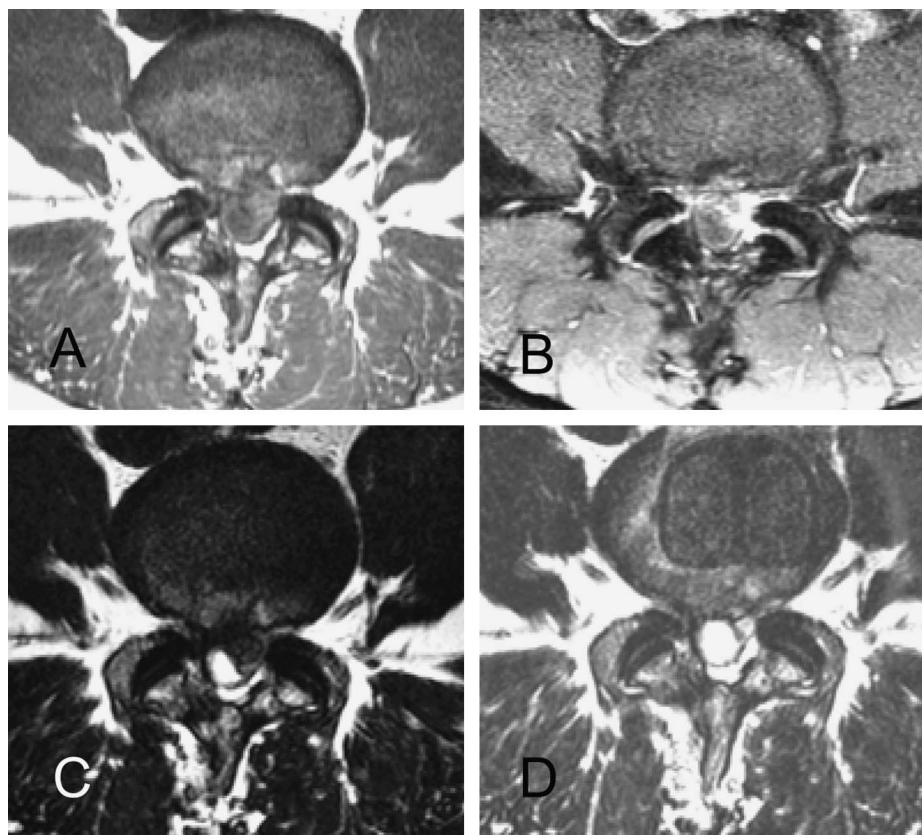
A and C, A series of axial T1-weighted (A) and T2-weighted (C) MR images revealing a large recurrent disc herniation. B, Postgadolinium T1-weighted images demonstrate peripheral enhancement of the herniation. D, Follow-up T2-weighted images obtained 3 days after ALIF show complete removal of the recurrent disc herniation and cage placement.
